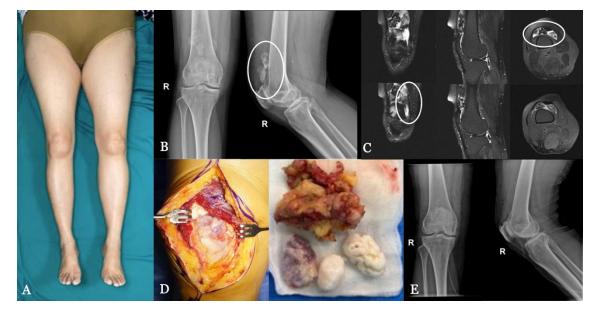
(A) Local condition of the lower extremity in a 66-year-old female patient with a lump over the left knee. (B) Knee X-ray depicting bony spurs in the suprapatellar region. (C) MRI revealing suprapatellar bursitis and femorotibial synovitis. (D) Intraoperative exposure of the joint and loose bodies; and loose bodies after removal. (E) Post-synovectomy knee X-ray imaging.
